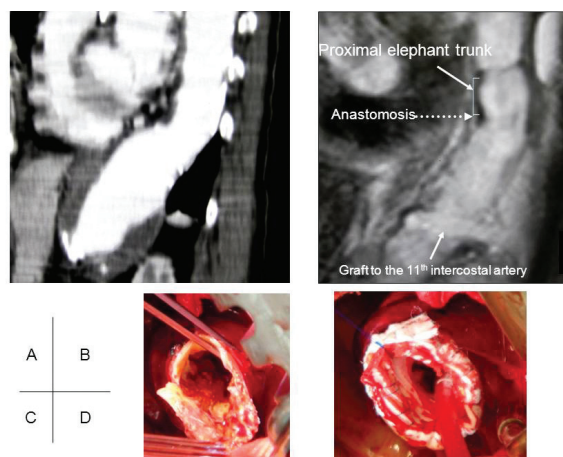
A, Preoperative computed tomography scan of a thoracoabdominal aortic aneurysm. A dense thrombus is present in the aneurysm. At the proximal anastomosis site, a long atheromatous lesion continues to the aneurysm. B, Postoperative magnetic resonance imaging of the thoracoabdominal aortic replacement. A proximal elephant trunk was firmly attached to the aortic wall without eversion. Stabilized atherosclerosis and a newly formed thrombus were detected between the aortic wall and the graft. C, Direct view of the inside of the aorta prior to the elephant trunk procedure. Dense, continuous atheromatous lesion can be seen. D, Proximal elephant trunk insertion technique. The softly inserted and fixed elephant trunk can be seen inside the aorta. The outside was also reinforced with a Teflon felt strip, and a stabilized proximal anastomosis site was made.
